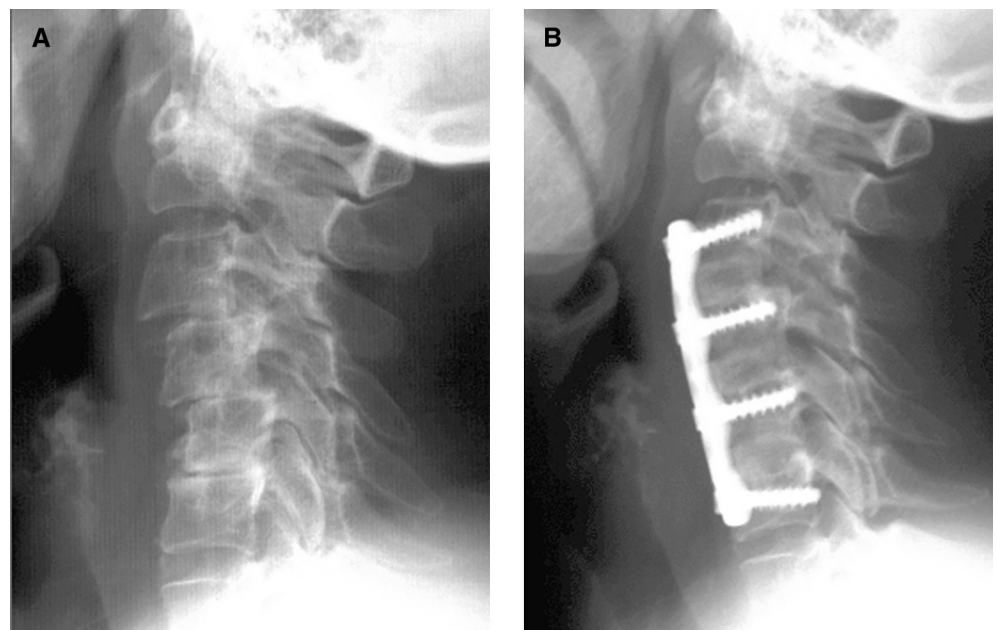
A, upright lateral C-spine x-ray showing loss of anterior column support in this patient who presented with cervical myelopathy. B, anterior column support was restored with a 3-level C3-6 cervical arthrodesis.
